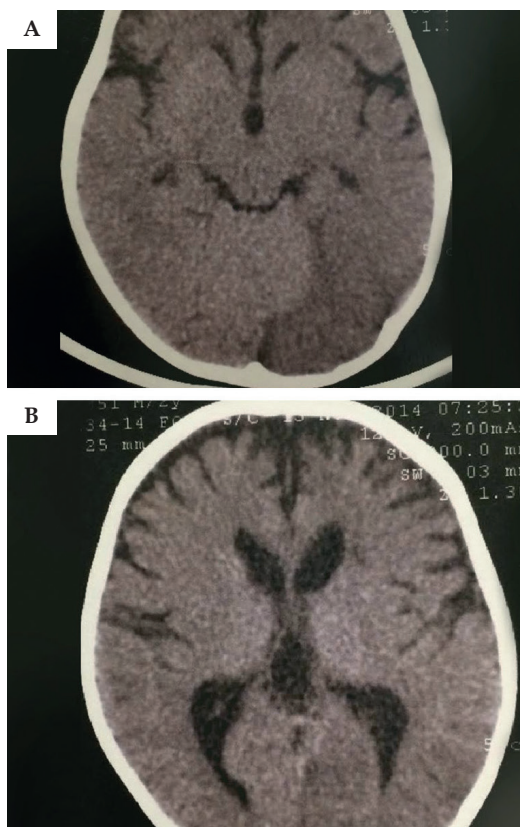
Computed tomography of the skull: left parietal-occipital hypodensity caused by sequelae of an ischemic insult evidenced in figures A and B
